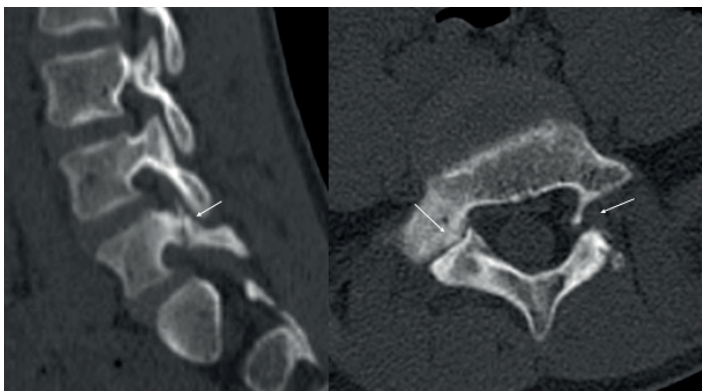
Bilateral pars interarticularis defects on CT in an adolescent patient. Sagittal and axial computed tomography images of the lumbar spine demonstrating bilateral defects of the pars interarticularis at the L5 level (arrows) in a 14-year-old male patient. The sagittal reconstruction shows cortical interruption of the pars region, while the axial image confirms bilateral involvement of the posterior elements, consistent with bilateral isthmic spondylolysis.
